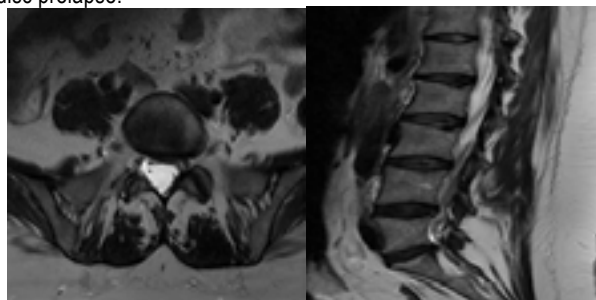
MRI lumbar spine T2 sagittal and axial view of the same patient shows no interval changes after 3 years with good outcome improvement of both lower back pain and leg pain.
